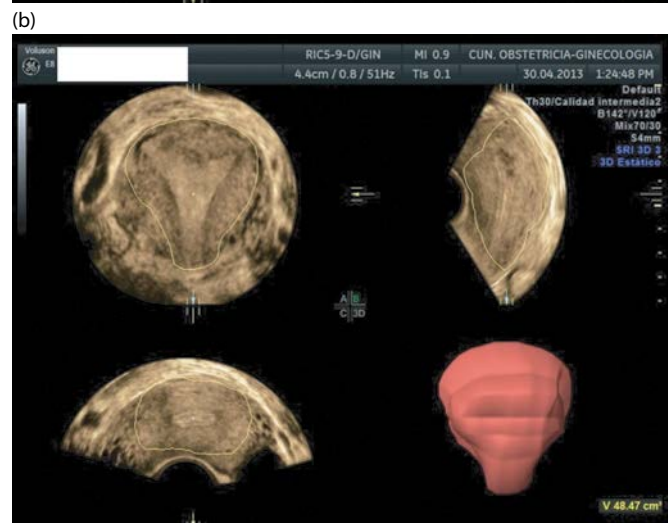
Estimation of myometrial infiltration using 3D ultrasound and the tumor/uterine volume ratio. We can calculate tumor volume (a) and uterine volume (b) and calculate a ratio (in this case, 0.08). As stated in the text, this method is not accurate.
